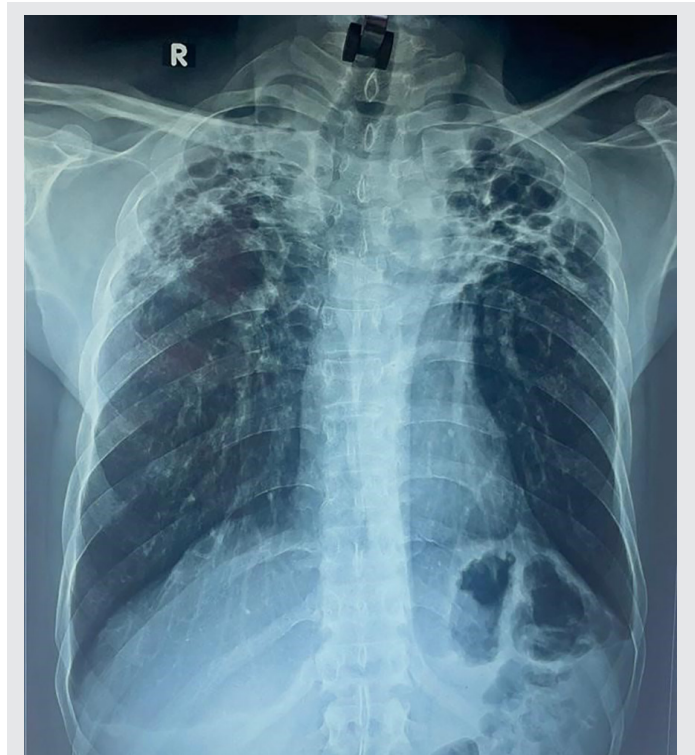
Chest x-ray reveals partial resolution of upper lobe cavitary infiltrates.
